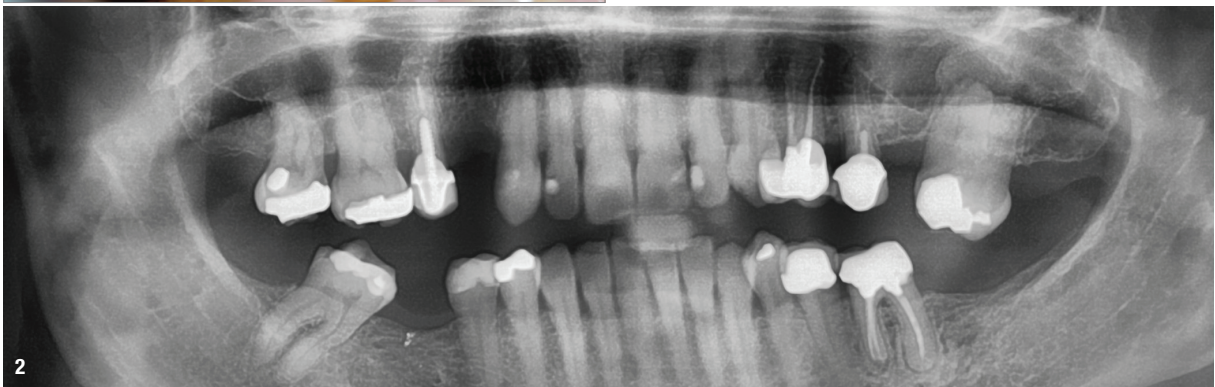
Situation before surgery. Fig. 2: Pre-op radiographic assessment confirming a well-healed situation.
